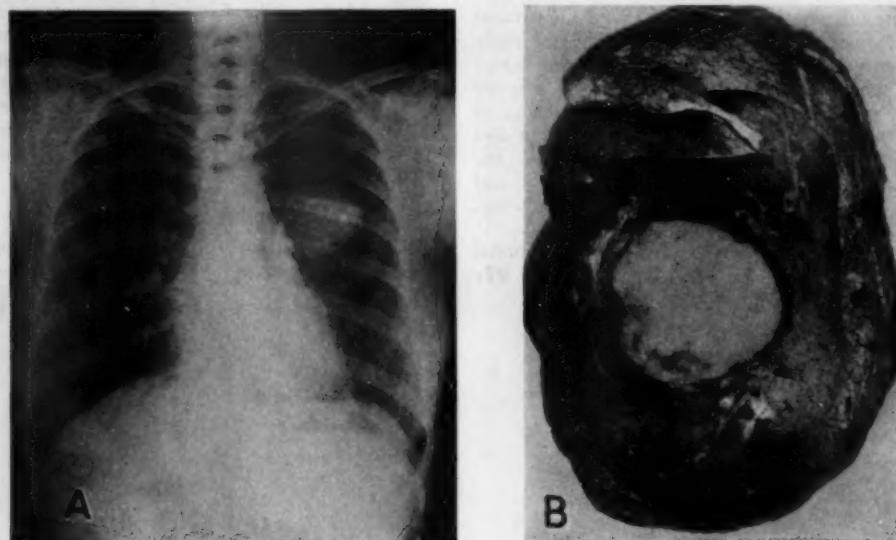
A, roentgenogram showing anterior-posterior view of a dense circumscribed shadow in the central and inner portion of the left pulmonary field.
